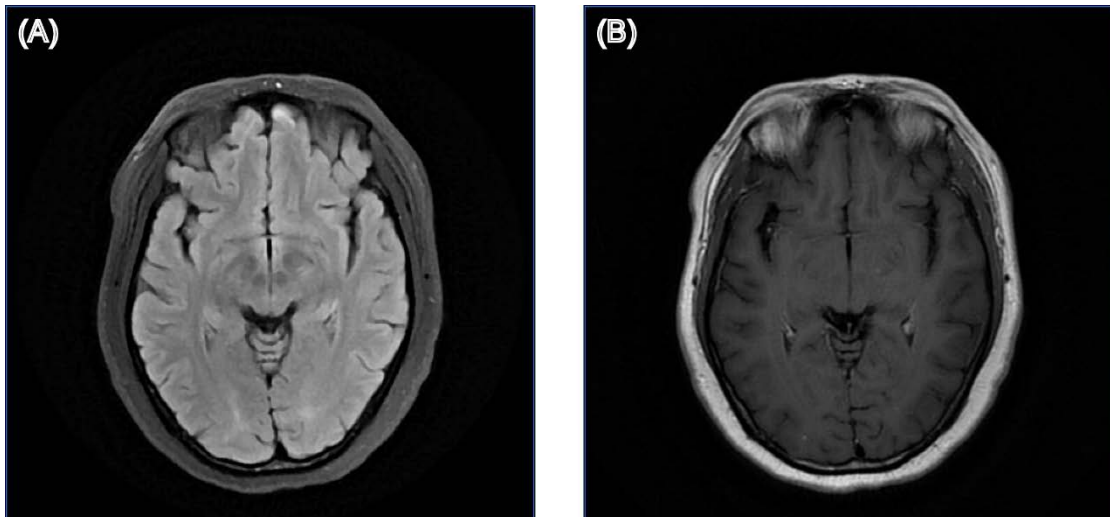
Structural brain MRI images of patient 15. (A) T2-weighted fluid-attenuated inversion recovery (T2-FLAIR) image; (B) Gadolinium-enhanced T1-weighted (Gd-T1w) image.
